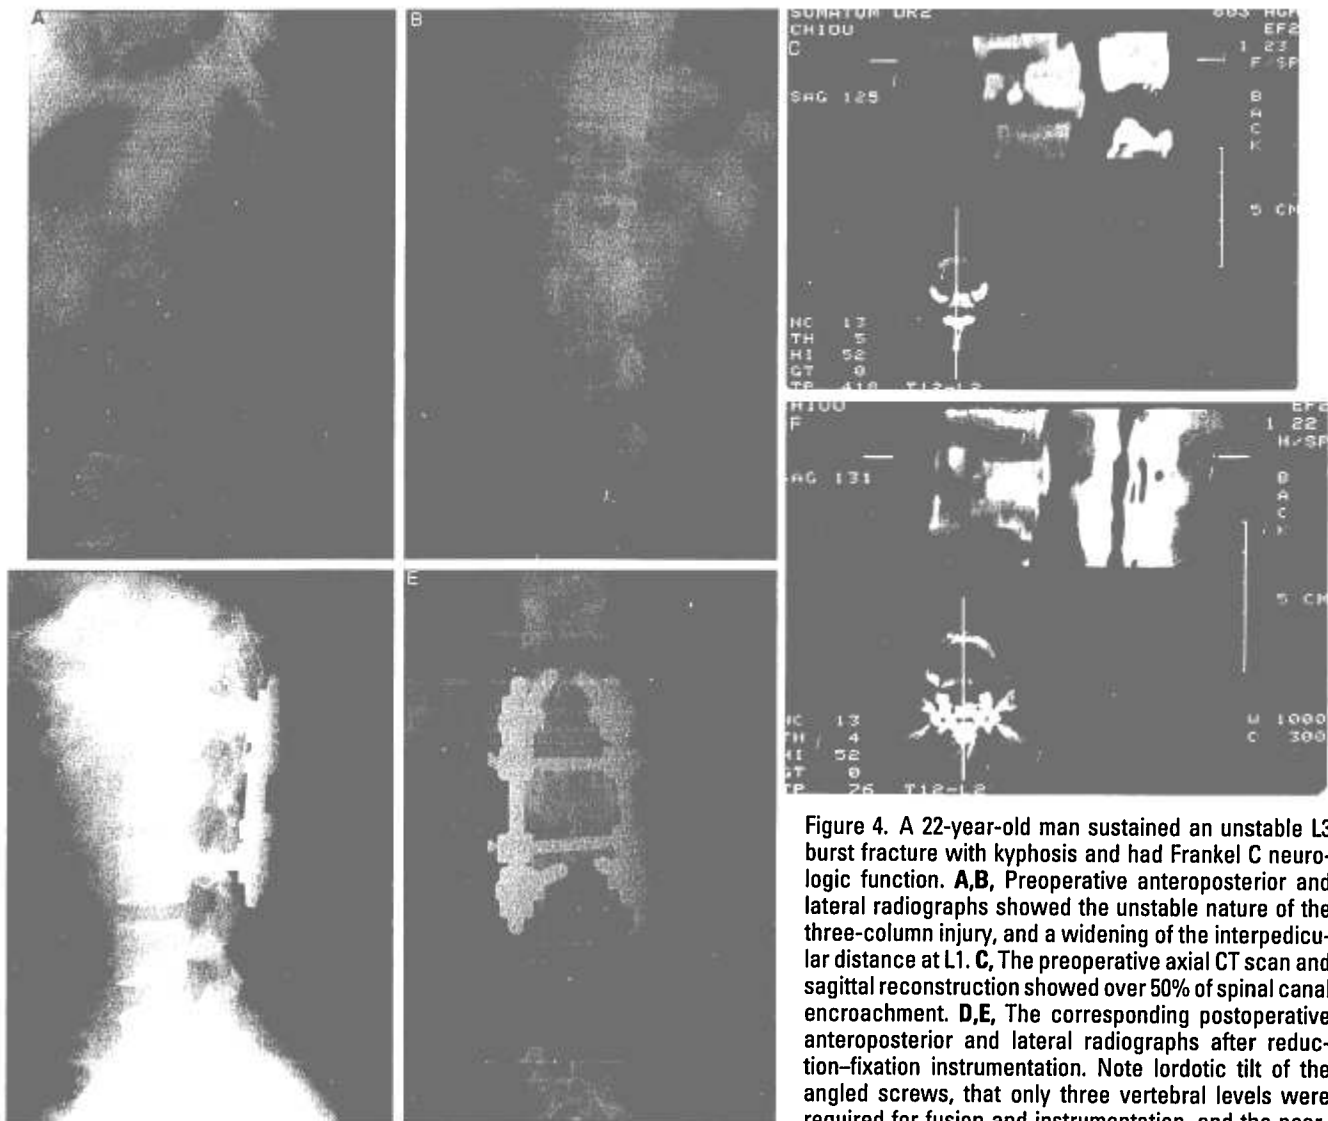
A 22-year-old man sustained an unstable L3 burst fracture with kyphosis and had Frankel C neurologic function. A,B, Preoperative anteroposterior and lateral radiographs showed the unstable nature of the three-column injury, and a widening of the interpedicular distance at L1. C, The preoperative axial CT scan and sagittal reconstruction showed over 50% of spinal canal encroachment. D,E, The corresponding postoperative anteroposterior and lateral radiographs after reduction-fixation instrumentation. Note lordotic tilt of the angled screws, that only three vertebral levels were required for fusion and instrumentation, and the near-anatomic reduction. F, The postoperative CT scan and sagittal reconstruction showed marked improvement of the spinal canal area. The patient recovered to Frankel E; hence, an anterior corpectomy was not indicated.
